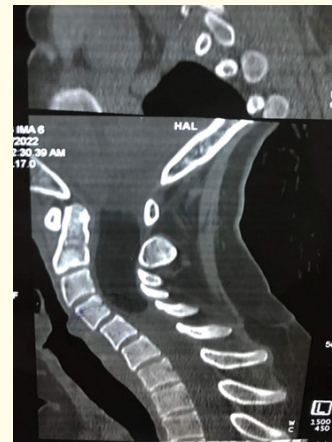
CT scan sagittal view
